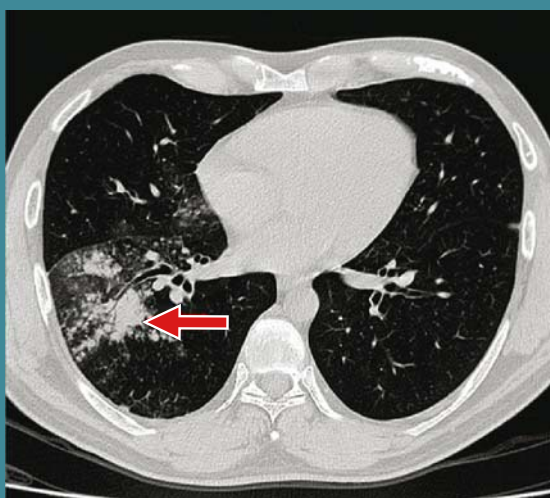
Chest CT scan with contrast (August 2018) - consolidation process, at the RLL level, at the time believed to be most likely with an infectious or inflammatory substrate
